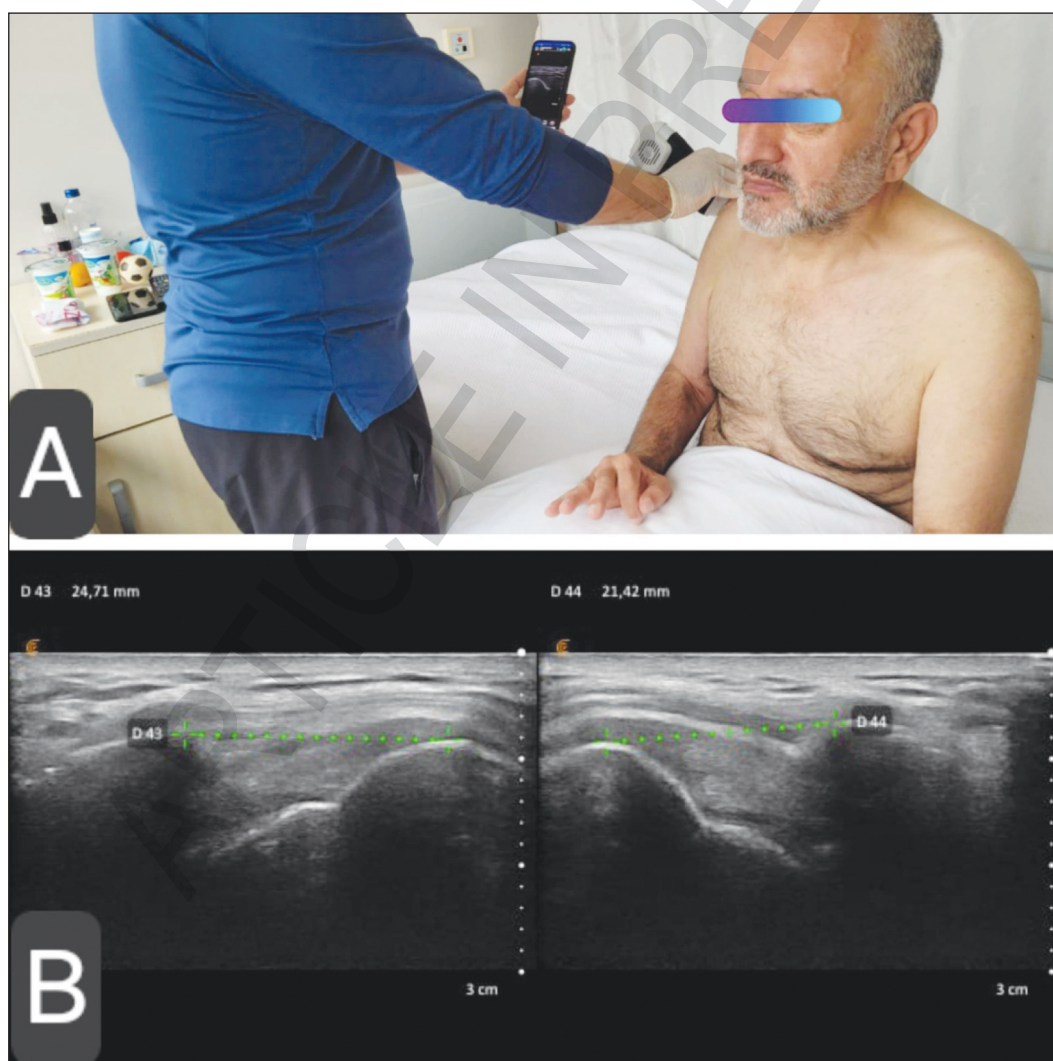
A) Bedside position of patients for ultrasonographic measurements of AGT distance; B) Coronal superiolateral B-scan of both shoulders showing AGT distance between the lateral border of the acromion and the nearest superior margin of the greater tuberosity. AGT difference between affected (24.71 mm) and unaffected shoulder (21.42 mm) is 3.29 mm (>2 mm), indicating subluxation.
